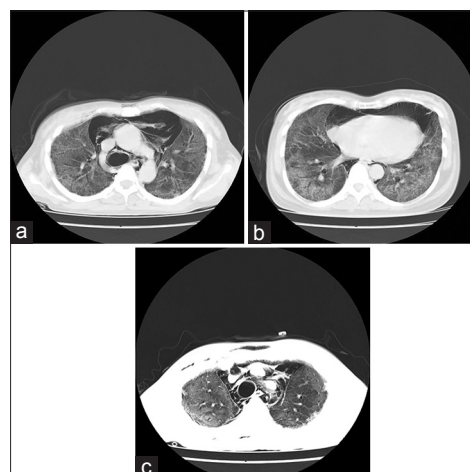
(a-c) Serial computed tomography images showing bilateral diffuse ground-glass opacities, mediastinal emphysema, and peripheral consolidation
